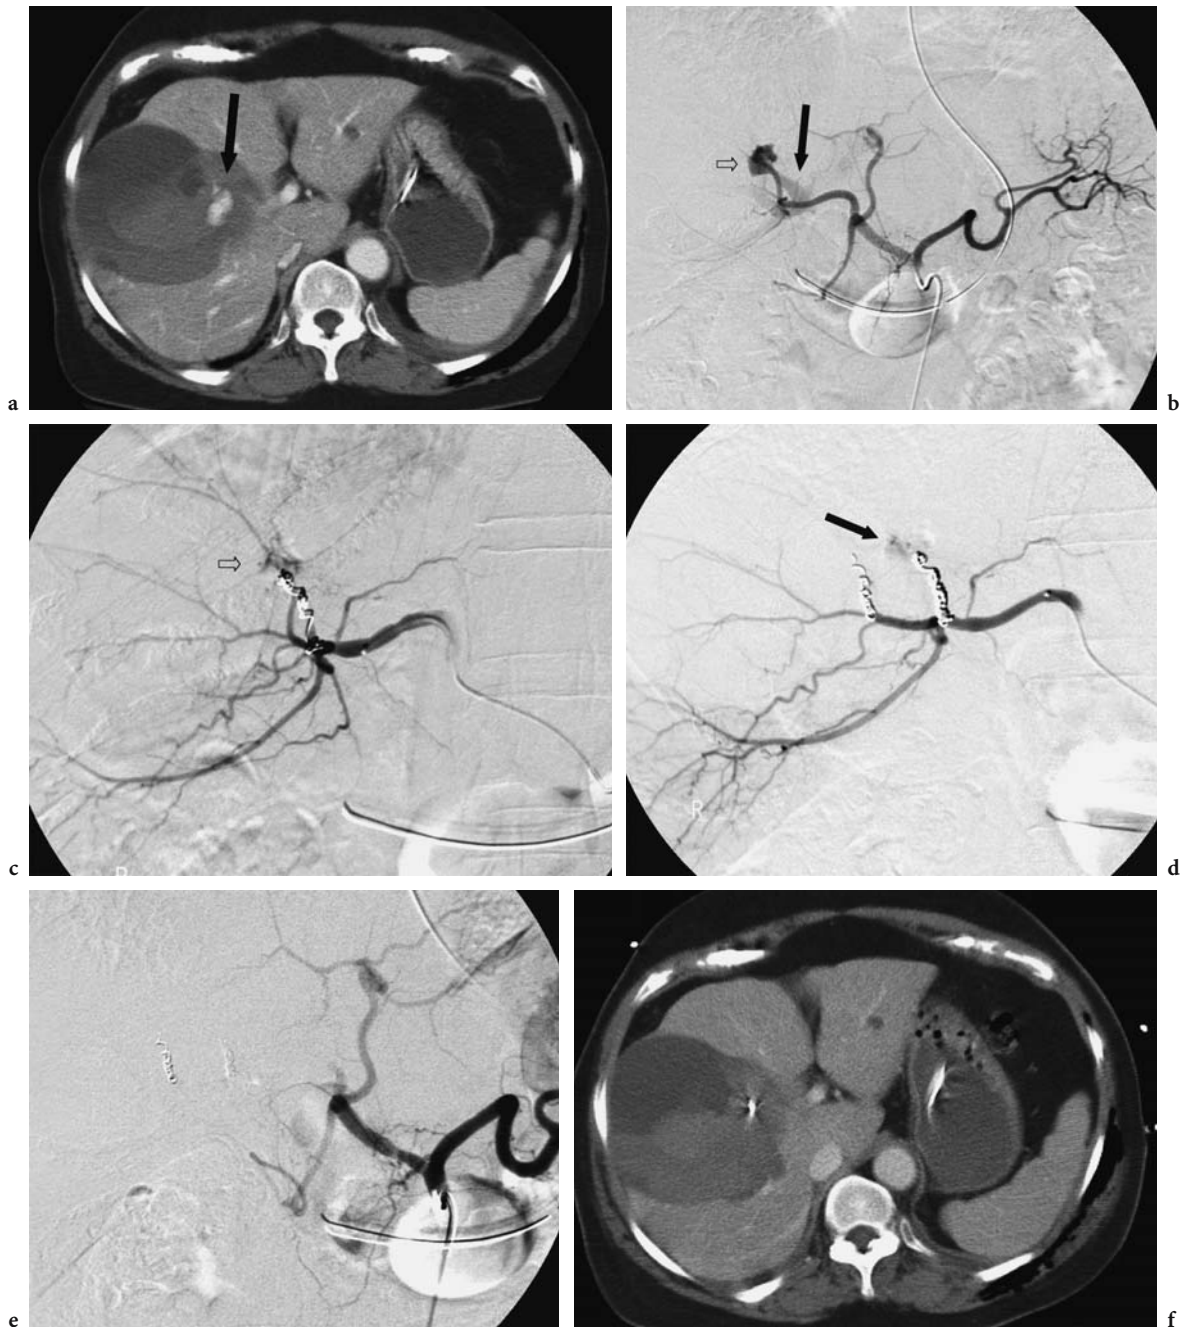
42 year-old man with abdominal and pelvis trauma. a Contrast-enhanced CT of the upper abdomen demonstrates a hematoma and active bleeding (*arrow*) in the right hepatic parenchyma. b Celiac trunk angiogram shows the arterial lesion (*short arrow*) with early venous drainage (*black arrow*). c Selective microcatheter placement in the feeding artery and embolization with coils is performed. Angiogram demonstrates the persistence of extravasation (*arrow*). d Hepatic angiogram, oblique view, after embolization of another feeding artery demonstrates the extravasation (*arrow*). e 20 minutes after embolization, there was a persistent extravasation from hepatic artery. The right hepatic artery is then embolized using Gelfoam torpedoes. f Contrast enhanced CT obtained 24 hours after embolization shows no more bleeding
